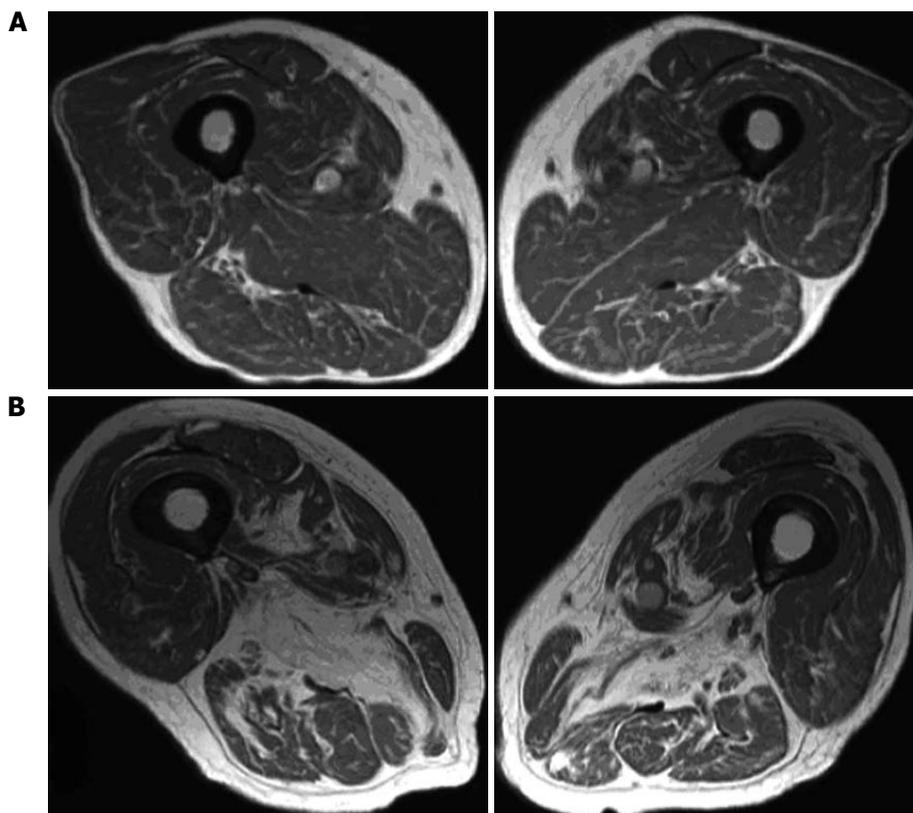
Magnetic resonance imaging of two different grades of fatty degeneration and atrophy involving thigh muscle in patients with vitamin D deficiency. A: Grade 1 (less than 30% of the volume of muscles involved); B: Grade 2 (30%-60% of the volume of muscles compromised).
